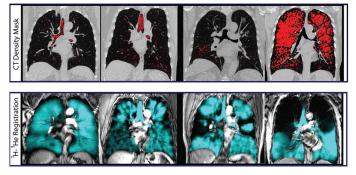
Comparison of CT Images (Top Panel) and MRI with Hyperpolarized Helium (Bottom Panel), with Progressive Emphysematous Destruction of the Lung²⁵
